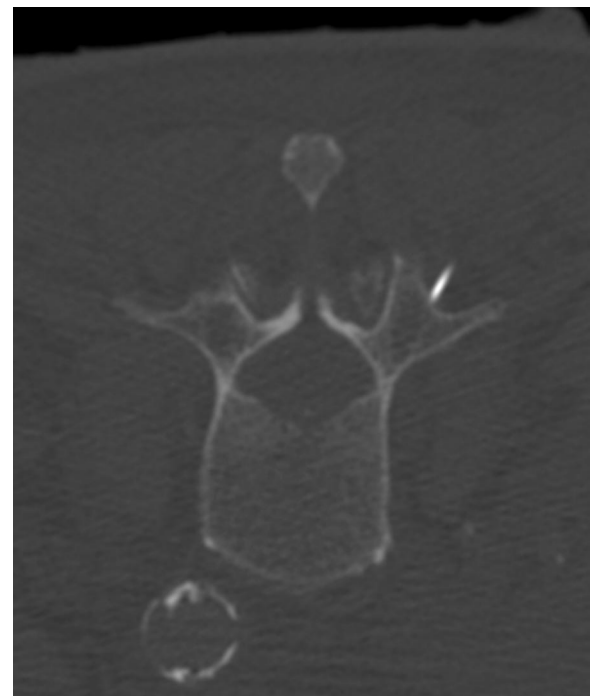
Axial transverse computed tomography scan (1-mm slice) without contrast dye showing a needle tip at the target position for a right-sided L2 medial branch block.
